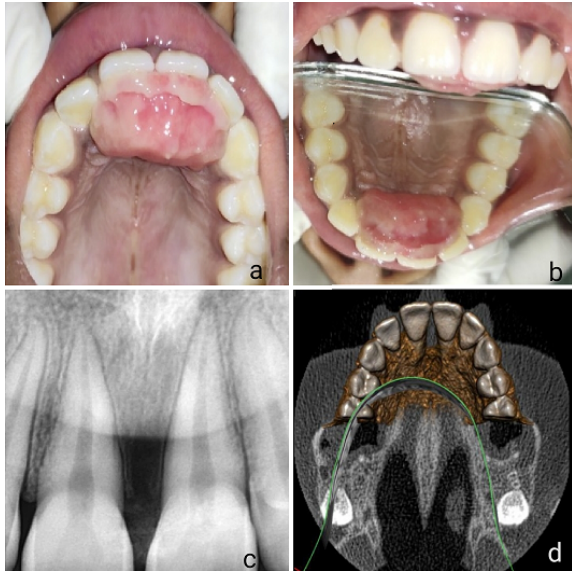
a: & b:-Pre op view, c:-IOPA, d:-CBCT
